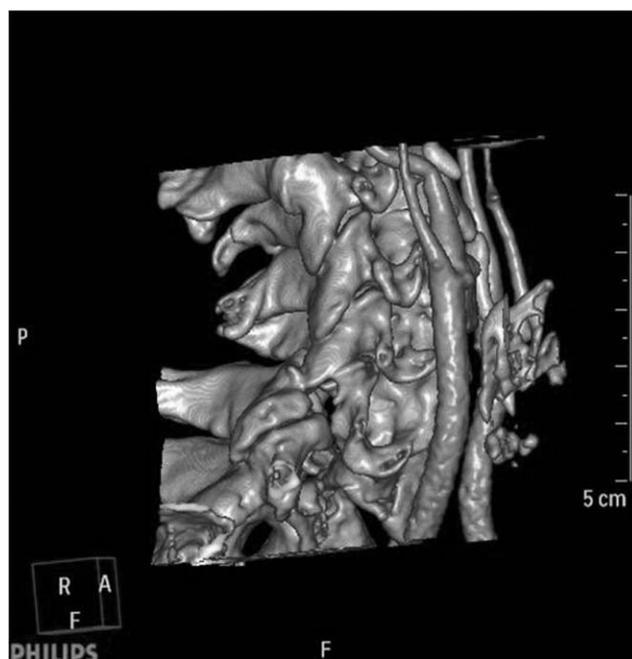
Initial computed tomography 3-dimensional reconstruction demonstrating C5-C6 facet dislocation from the anterior oblique view.
